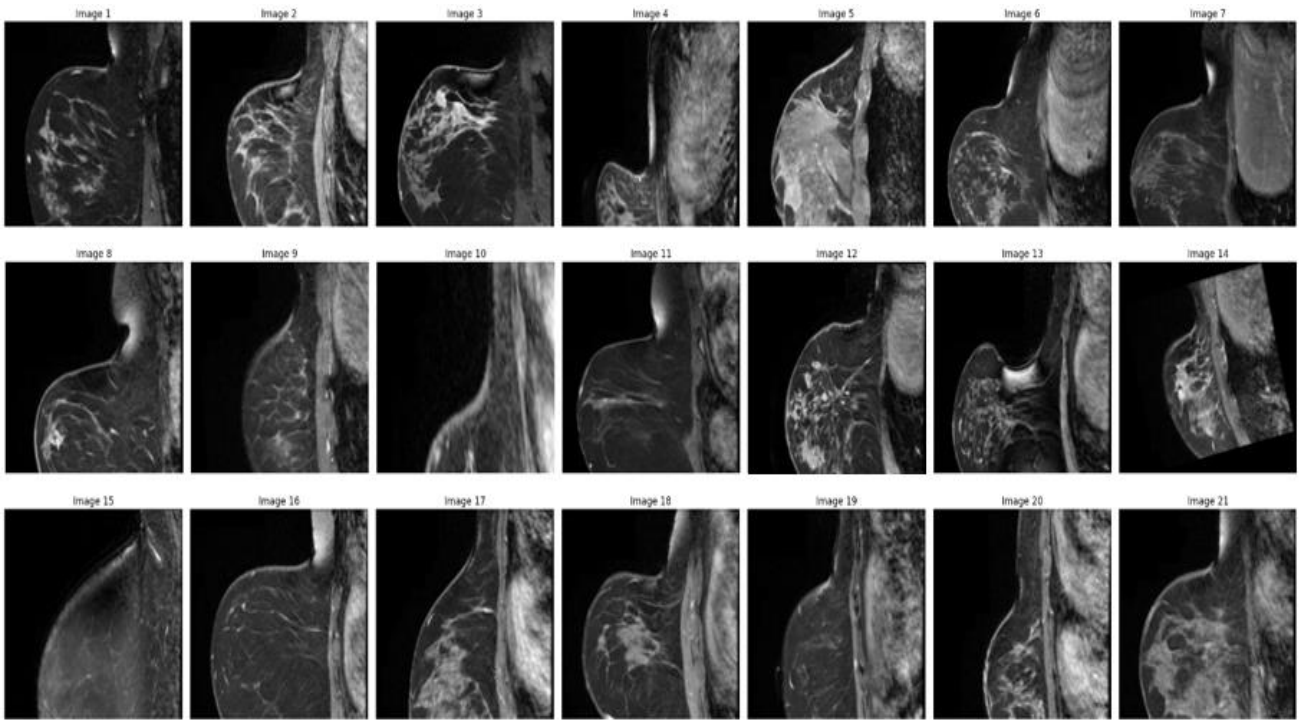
Pre-processed MRI images related to patients with tumor on the right breast
